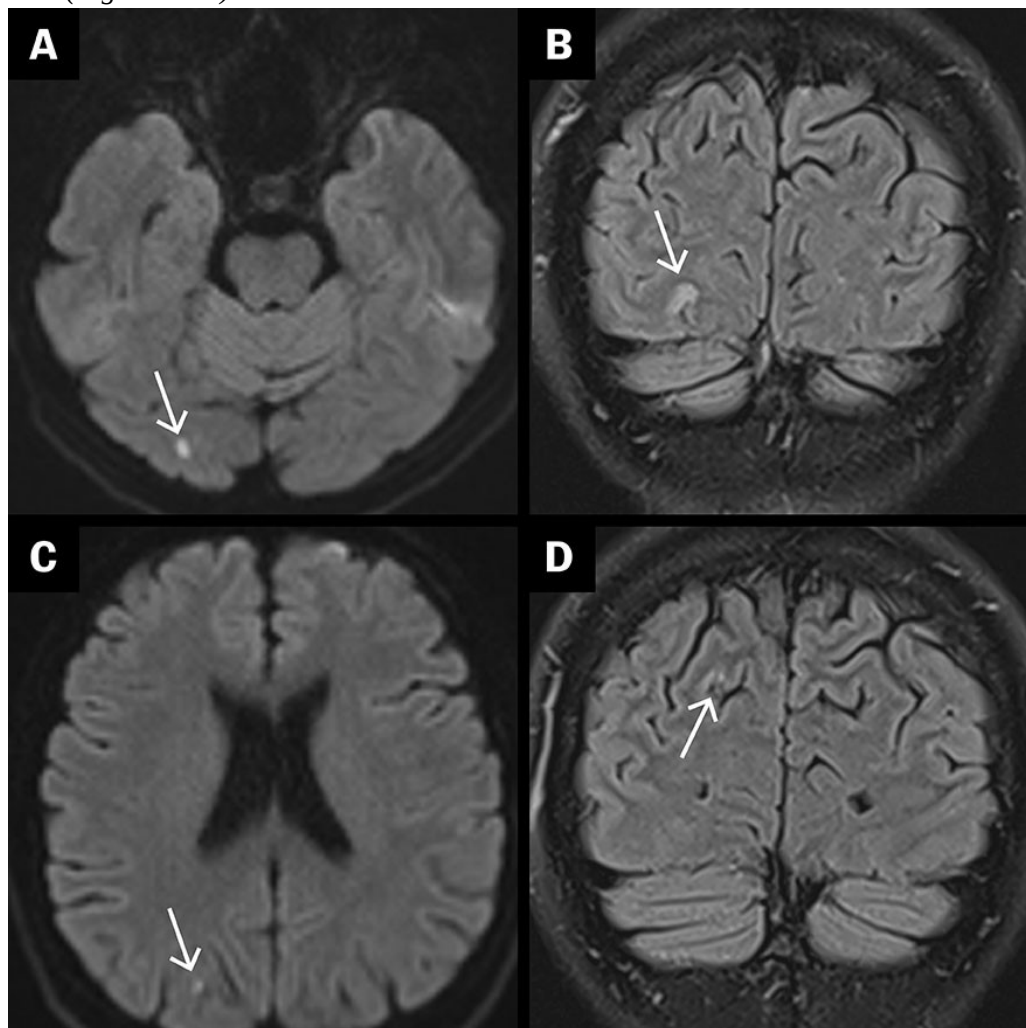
MRI of the brain on day 2. A) Diffusion-weighted imaging (b1000) showed a lesion with high signal in the right occipital lobe, with corresponding low values on the ADC map. These findings indicate diffusion restriction, consistent with cytotoxic oedema as seen in acute ischaemia. B) FLAIR MRI (coronal section) showed high signal corresponding to the findings
